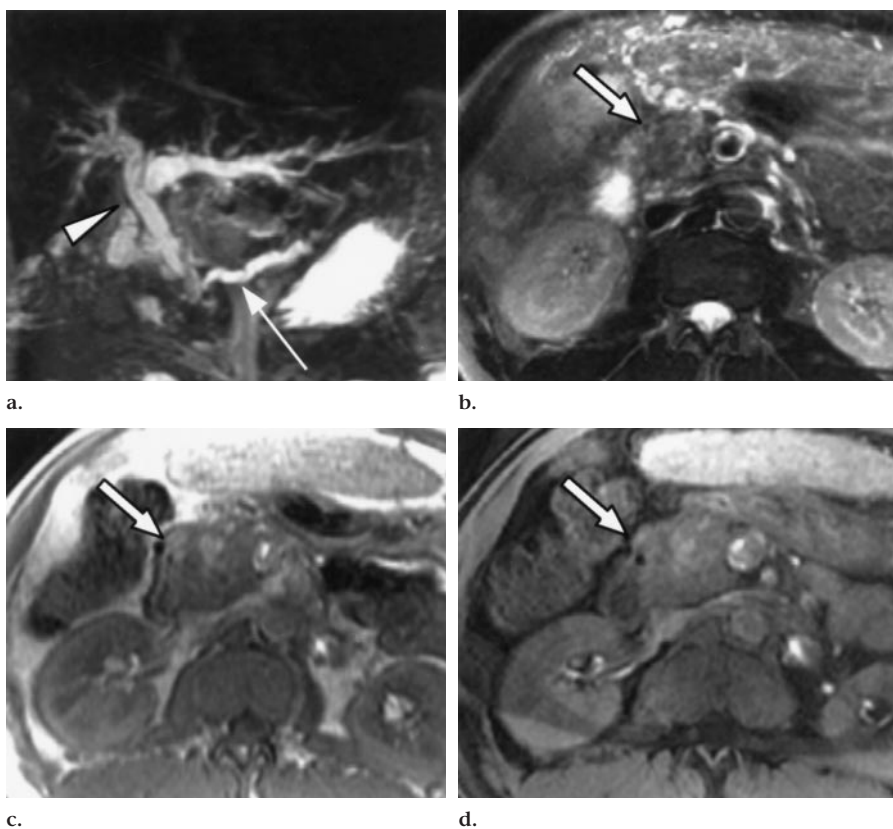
Chronic pancreatitis in a 50-year-old man. (a) Coronal maximum intensity projection image reconstructed from MRCP images (fast SE, 12,000/260) shows dilatation of the biliary tree (arrowhead) and pancreatic duct (arrow). A malignant cause was suggested on the MRCP image. (b) Transverse less heavily T2-weighted image (fast SE, 9,000/120), (c) transverse precontrast in-phase GRE image (120/4.2), and (d) transverse postcontrast fat-saturated GRE image (140/1.8) show focal enlargement and heterogeneous signal intensity of the pancreatic head (arrows). Pancreatic carcinoma was suggested at MR examination; however, pancreaticoduodenectomy revealed chronic pancreatitis and fibrosis but no tumor.
